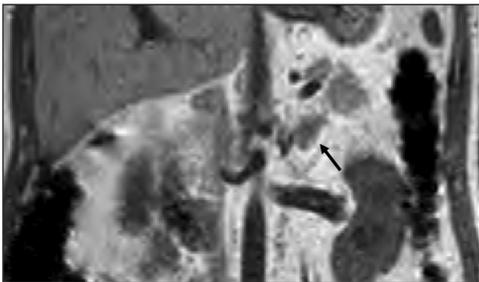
In-phase coronal 1.5T magnetic resonance image (Echo time (TE) 4.6 msec) obtained in June 2009 demonstrates the same left adrenal nodule (black arrow).
